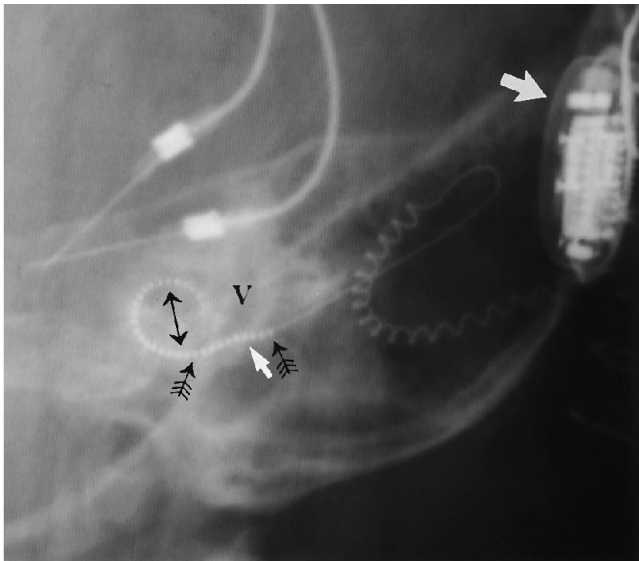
Intraoperative Stenver's view shows a normally inserted electrode array. Between the array of 22 active electrodes (*two-headed arrow*) and the receiver/stimulator (*large white arrow*) are 10 electrically inactive stiffening rods (*small black arrows*). The stiffening rods, which provide mechanical support during insertion, are radiographically identical in appearance to the electrodes. Note the gentle curve of the array within the first turn of the cochlea with regular spacing between the electrodes. The depth of insertion is estimated by counting the number of electrodes or stiffening rods relative to the cochlear promontory (*small white arrow*), which is the air-bone interface below the vestibule (*V*). In this example there are 3 stiffening rods lateral to the cochlear promontory, indicating an insertion of 22 electrodes and 7 stiffening rods. This is termed a *full insertion*, because all 22 active electrodes are intracochlear.
